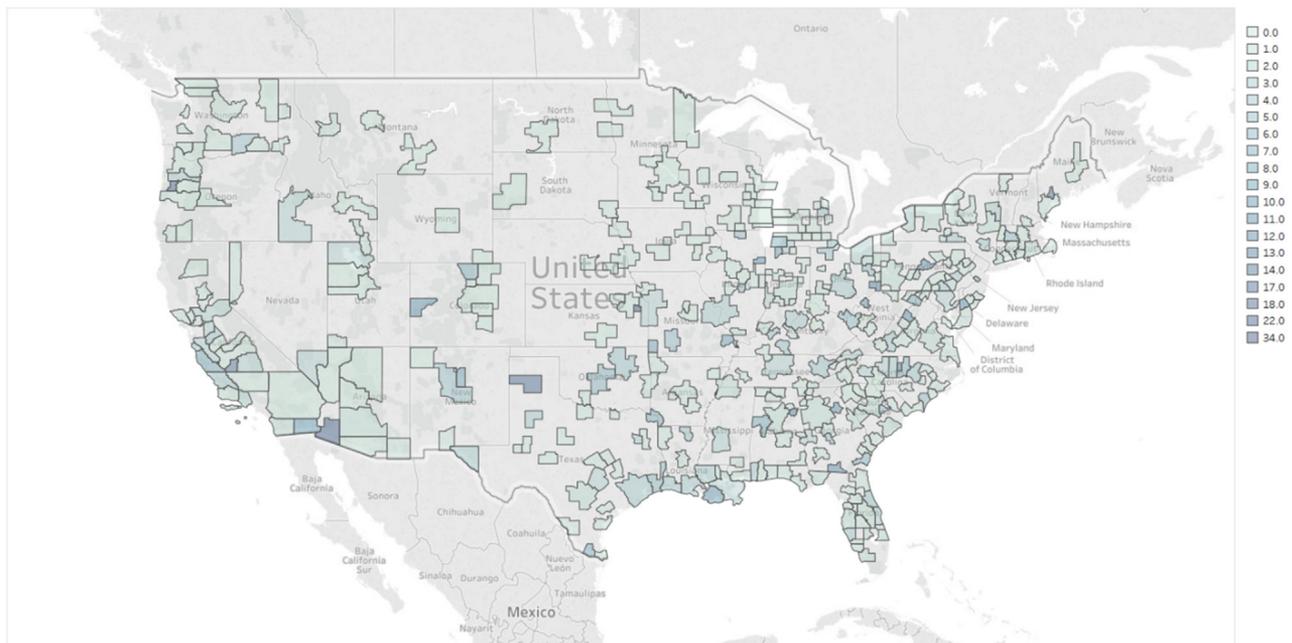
Routine use of MRI for the diagnosis of CTS by MSA in the United States in 2012.
